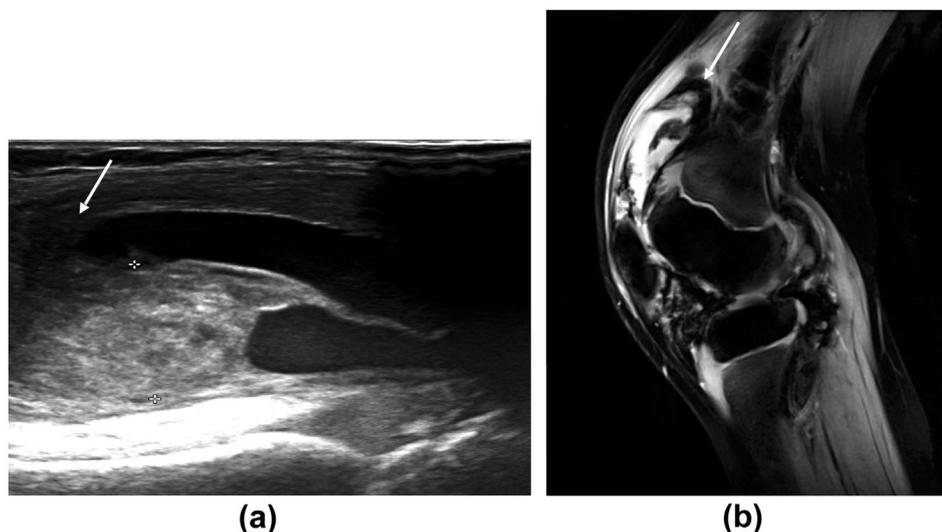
An 8-year-old boy with known haemophilic arthropathy with a severe HJHS score of 14, underwent musculoskeletal US (US-US protocol) of the left knee, which revealed grossly hypertrophied synovium (+) with marked hypoechoic areas (white arrow) within the anterior sagittal central view (a) and this corresponds to the hypointense area in the gradient sequences of MRI (b) confirming the gross haemosiderin deposition.
